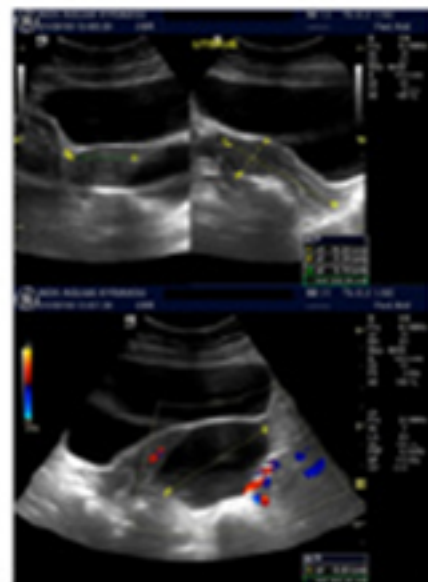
Pelvic ultrasound a. Uterus; b. Ovarian cyst
